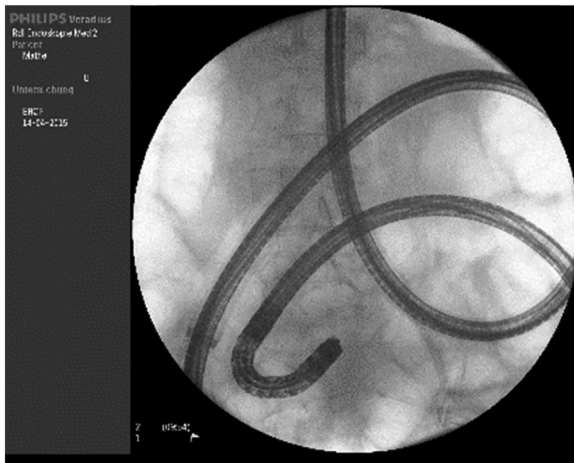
Balloon enteroscopy: Plain abdominal X-ray. The endoscope can be easily recognized. *Courtesy: Prof. S. v. Delius, Klinikum rechts der Isar.*
